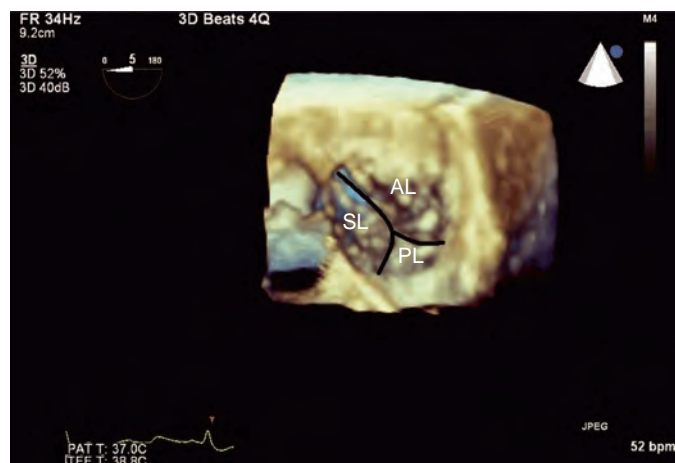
Three-dimensional transesophageal echocardiographic image of the tricuspid valve displayed in the surgeon's view. AL, Anterior leaflet; PL, posterior leaflet; SL, septal leaflet.
